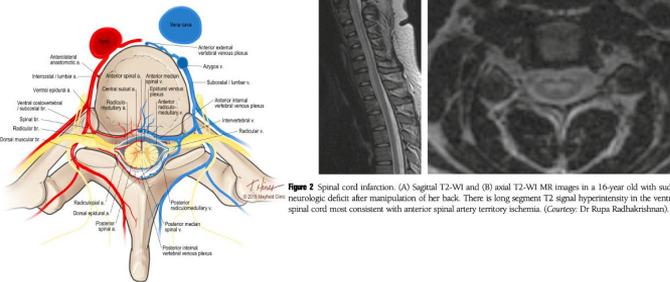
Spinal cord infarction. (A) Sagittal T2-WI and (B) axial T2-WI MR images in a 16-year-old with sudden onset neurologic deficit after manipulation of her back. There is long segment T2 signal hyperintensity in the ventral cervical spinal cord most consistent with anterior spinal artery territory ischemia. (Credit: Dr Rupa Radhakrishnan).
